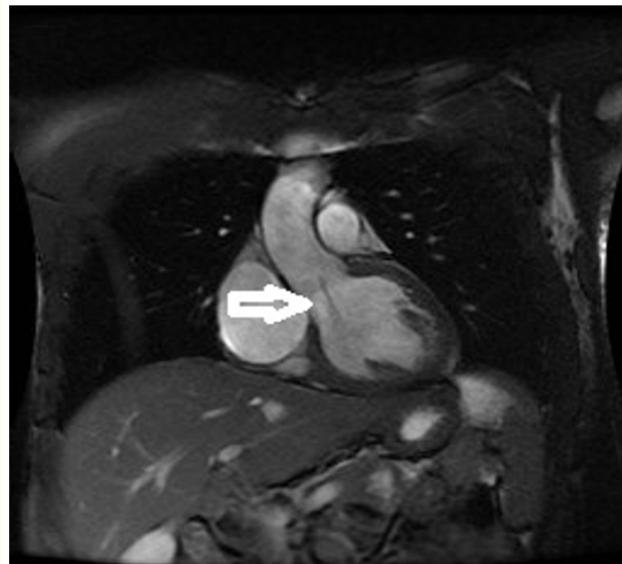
Cardiac MRI showing the presence of LE.
